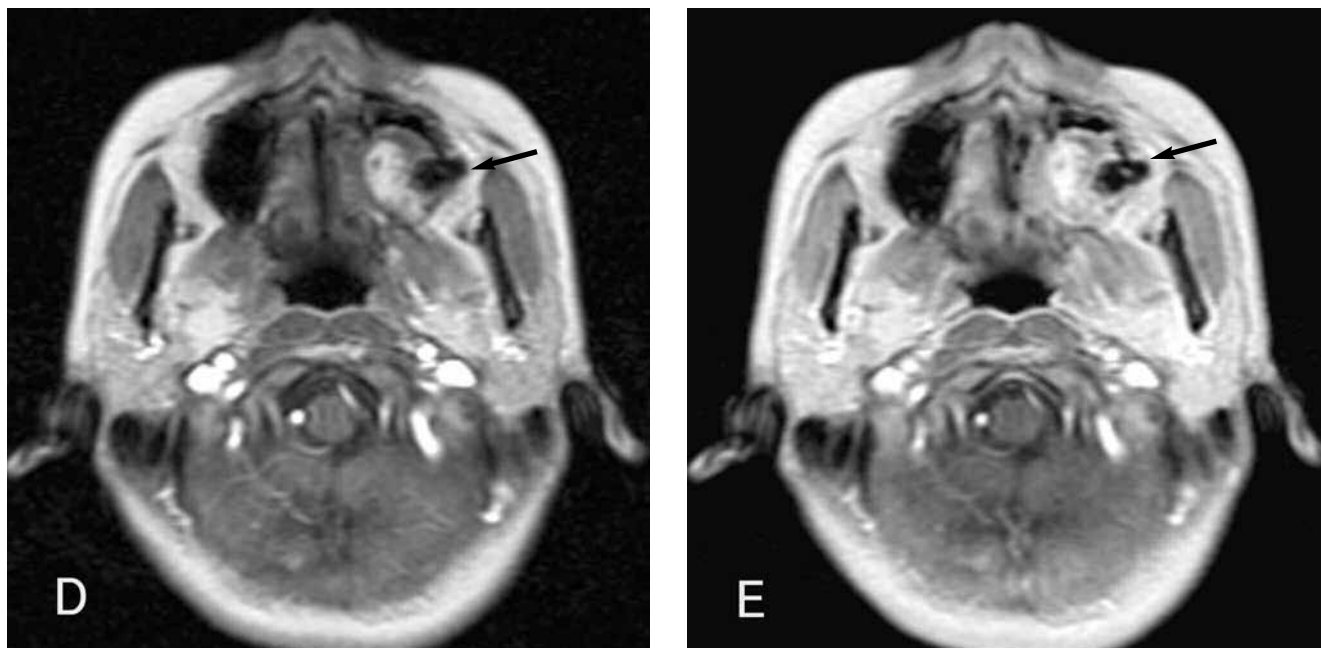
Dynamic axial MR images (gradient echo, TR = 75, TE = 4 msec, FA = 60).
